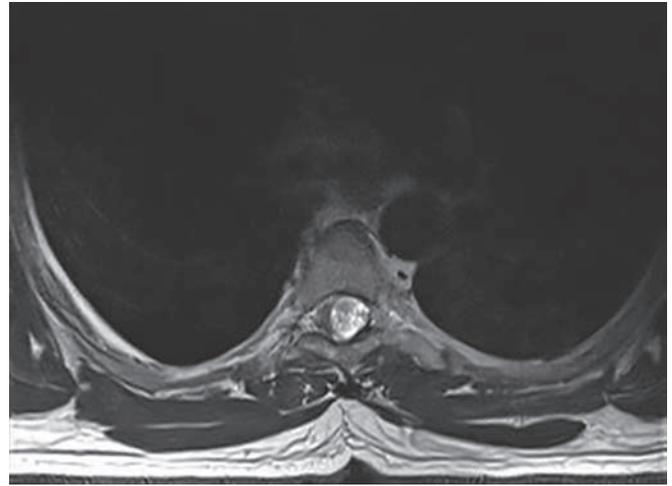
Axial contrast MRI image of the dorsal spine showing bright contrast enhancement of the intradural extramedullary tumor
